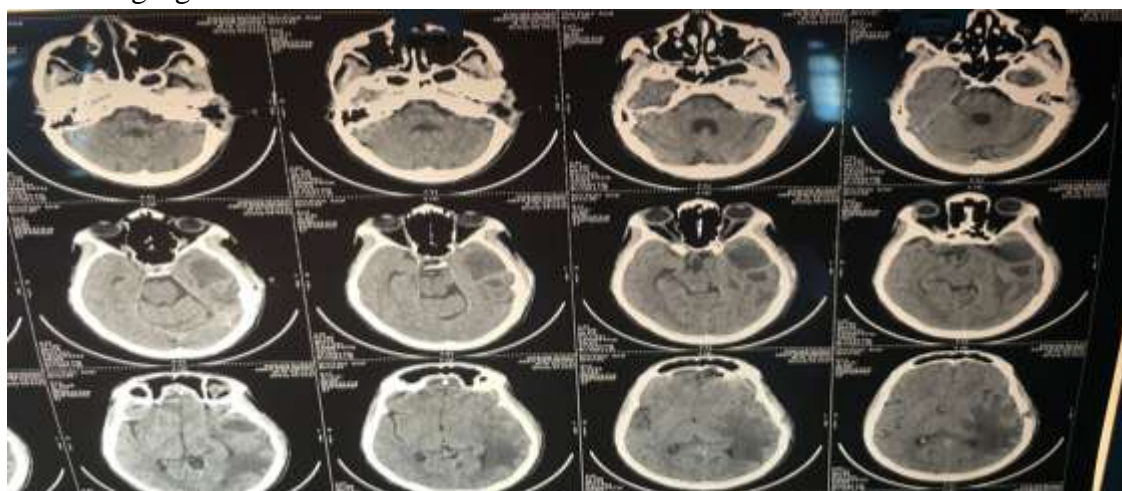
3 MRI brain (axial section) showing right cerebellar abscess
